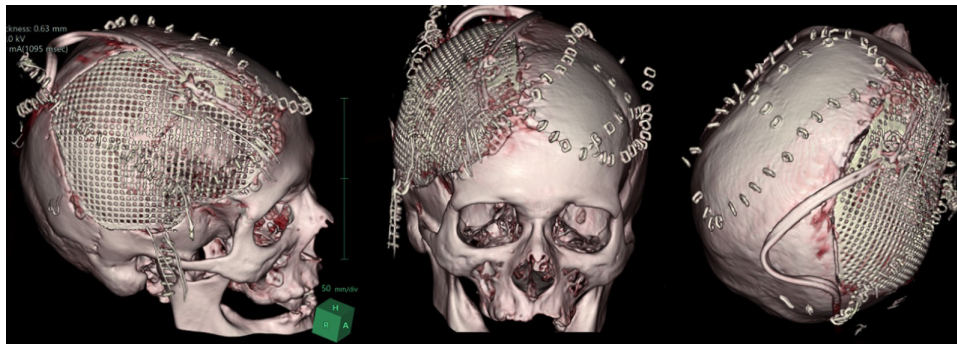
Postoperative CT scans.
